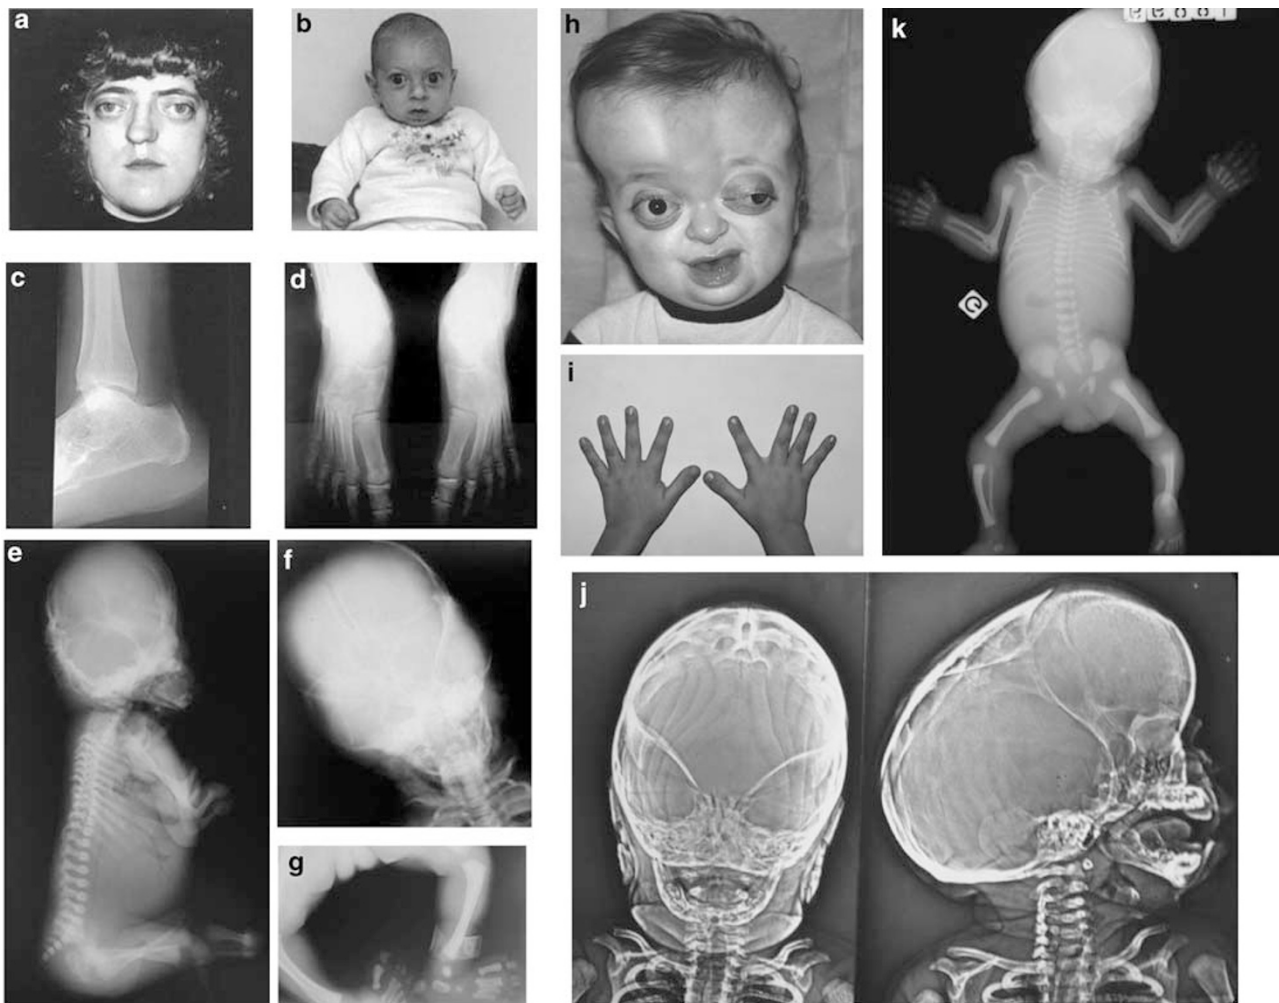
Clinical and radiological features of patients with JW phenotype and PS. (a, b) Presence of brachycephaly, midface hypoplasia, facial dysmorphism and proptosis in a mother and her son with JW phenotype. (c, d) Note partial tarsal fusion and extra delta-shaped small bone between the first and the second phalanx of the left hallux in the boy (at 15 years) and complete tarsal fusion in the mother. (e) Lateral and frontal radiographs of a 25-week-old foetus with PS carrying the Y340C *FGFR2* mutation showing humero-radio-ulnar synostosis and sacral anomalies. (f) Cloverleaf skull. (g) Abnormal shape of the first phalanges of big toes. (h) Severe proptosis, marked brachycephaly with undersized cranial vault, (i) mild syndactyly and flat thumbs in a patient with PS carrying a K641R *FGFR2* mutation. (j) Facial and lateral radiographs of a Pfeiffer patient carrying a C342R *FGFR2* mutation, showing severe multisynostoses of sagittal and coronal sutures responsible for severe scaphocephaly. (k) Radiograph of a 29-week-old foetus with PS carrying the W290C *FGFR2* mutation showing brachycephaly with cloverleaf skull, bilateral humero-radio-ulnar synostosis and large and deviated thumbs.
